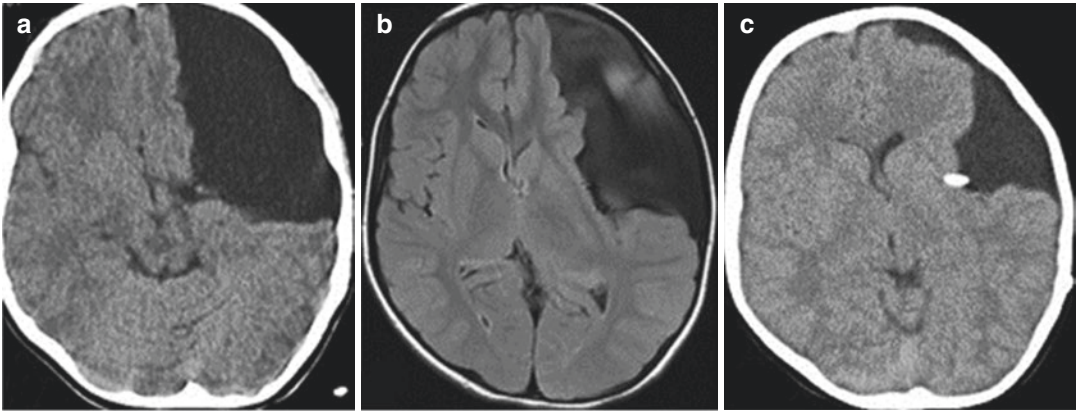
Left frontoparietal arachnoid cyst in an 11-year-old girl. The patient presented with a headache complaint. Neurological examination was normal. Preoperative CT scan (a) and T1-weighted axial MRI (b) examinations demonstrate a arachnoid cyst in the left
